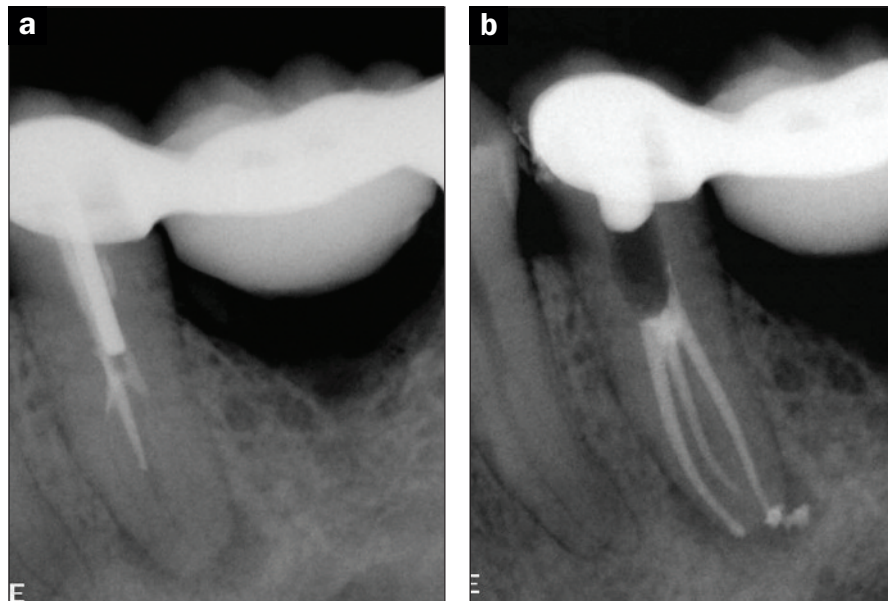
Conventional retreatment case completed with bioceramic obturation technique: (a) pre-op x-ray, and (b) post-op x-ray. (Case courtesy of Dr. Brad Trattner.)
